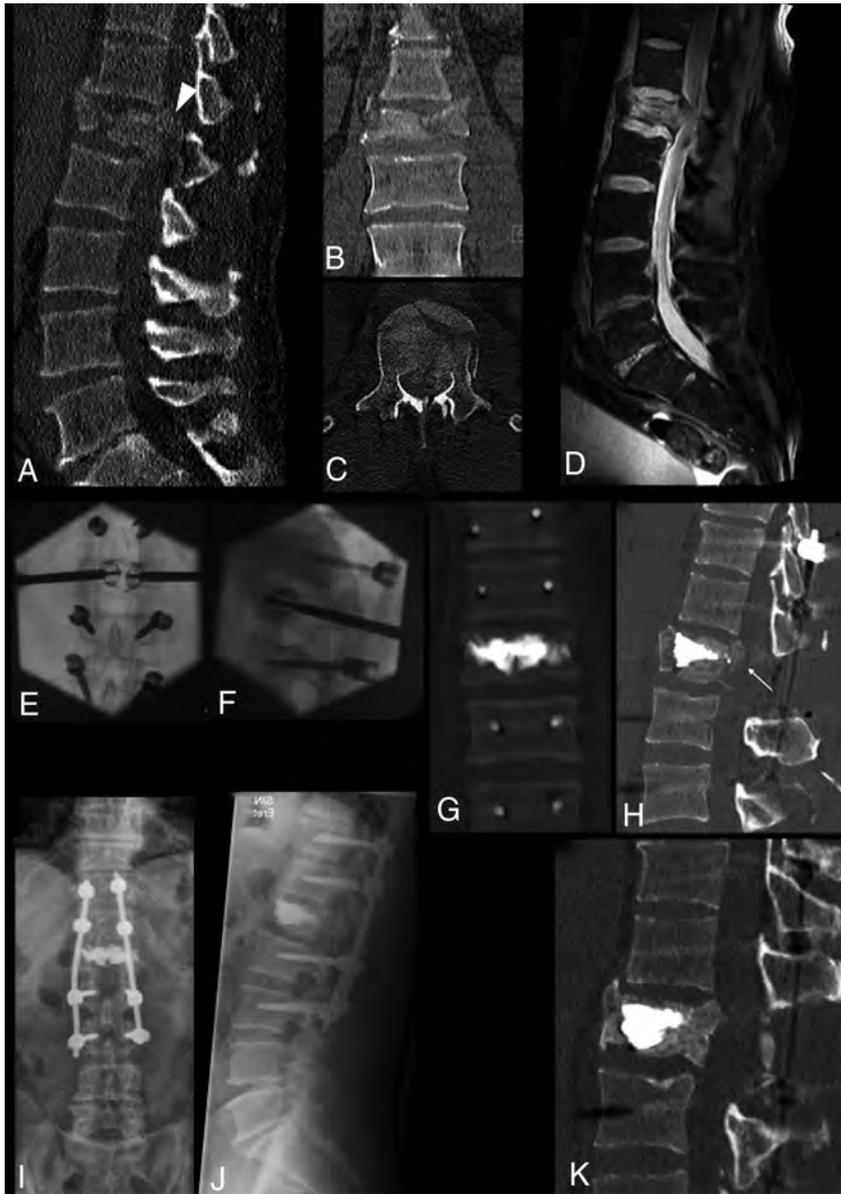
Complete burst fracture of L1 following high-energy trauma in a 40-year-old man with marked vertebral body fragmentation (A–C) and posterior wall retropulsion (*arrowhead*, A). Sagittal fat-saturated proton density MR image (D) shows an epidural hematoma and compression of the conus medullaris, but the patient was neurologically intact. The patient underwent surgical treatment in a hybrid operation room, including, in sequence, L1 decompressive laminectomy, pedicular screw placement, fracture reduction and vertebral body augmentation with percutaneous bilateral SpineJack, and posterior stabilization with spinal rods (E and F). Postprocedural CT (G and H) shows fracture and kyphosis reduction and, most important, central canal clearance (*arrow*, H) through ligamentotaxis. Notably, no maneuvers of direct fragment impaction or of posterior fracture distraction were performed. Follow-up imaging with standing plain films at 6 months (I and J) and with CT at 12 months (K) shows preserved vertebral body height and alignment and osseous healing around the cement cast. In this case, a more invasive procedure of corpectomy and anterior column stabilization could be successfully avoided by armed kyphoplasty.
